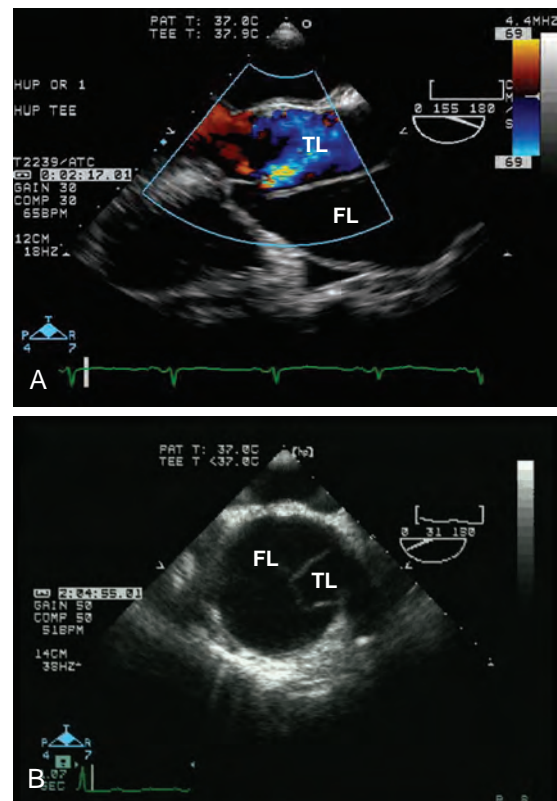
Transesophageal echocardiographic midesophageal long-axis image of the aortic valve (A) and short-axis image of the ascending aorta (B) in a patient with a type A aortic dissection. An intimal flap separating the true lumen (TL) of the aorta with the false lumen (FL) was demonstrated in the aortic root and ascending aorta. Extension of the dissection into the aortic root may cause aortic regurgitation or coronary insufficiency.
